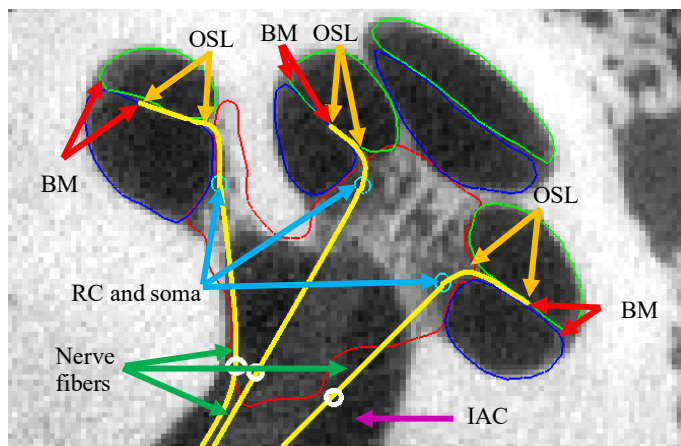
A 2D view of a μ CT image where scala tympani, scala vestibuli and modioli are shown with blue, green, and red contours; RC and IAC endpoints are shown with light blue and white circles; and nerve fibers are shown with yellow lines, respectively.
